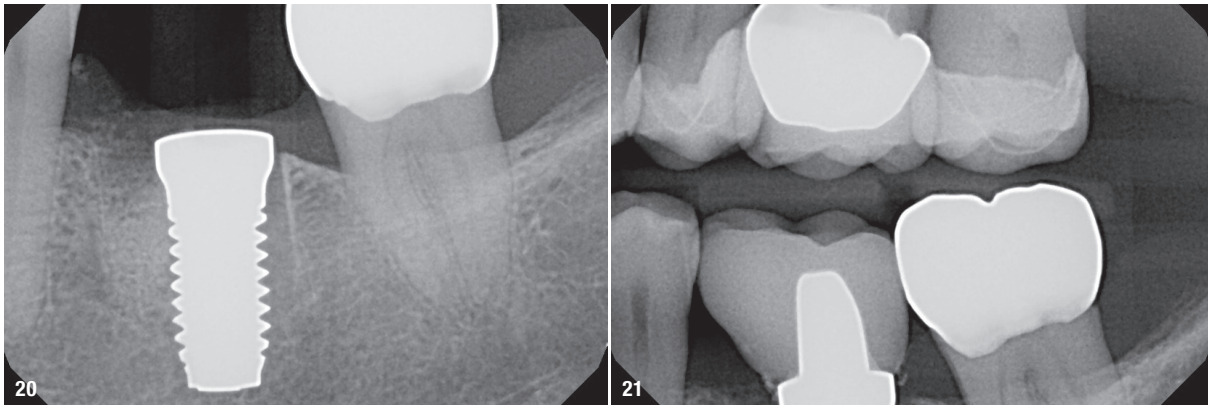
Radiograph of the same implant after four months of healing. Fig. 21: Bitewing radiograph of the crown after cementation.
